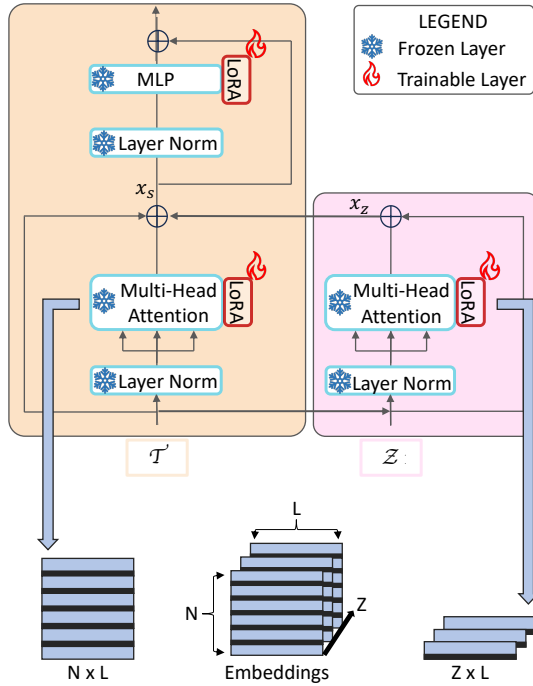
Cross-slice attention mechanism. We employ cross-slice attention to account for both space and depth relationships in the mp-MRI images through two linked branches in each transformer block, one of them receiving transposed inputs.
